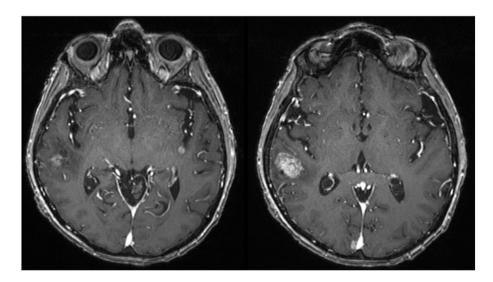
MRI: Postradiotherapy images with new metastatic lesions. A. 4 mm metastatic lesion in Left frontal lobe abutting the sylvian fissure. B. 6 mm metastatic lesion in the right occipital lobe.
